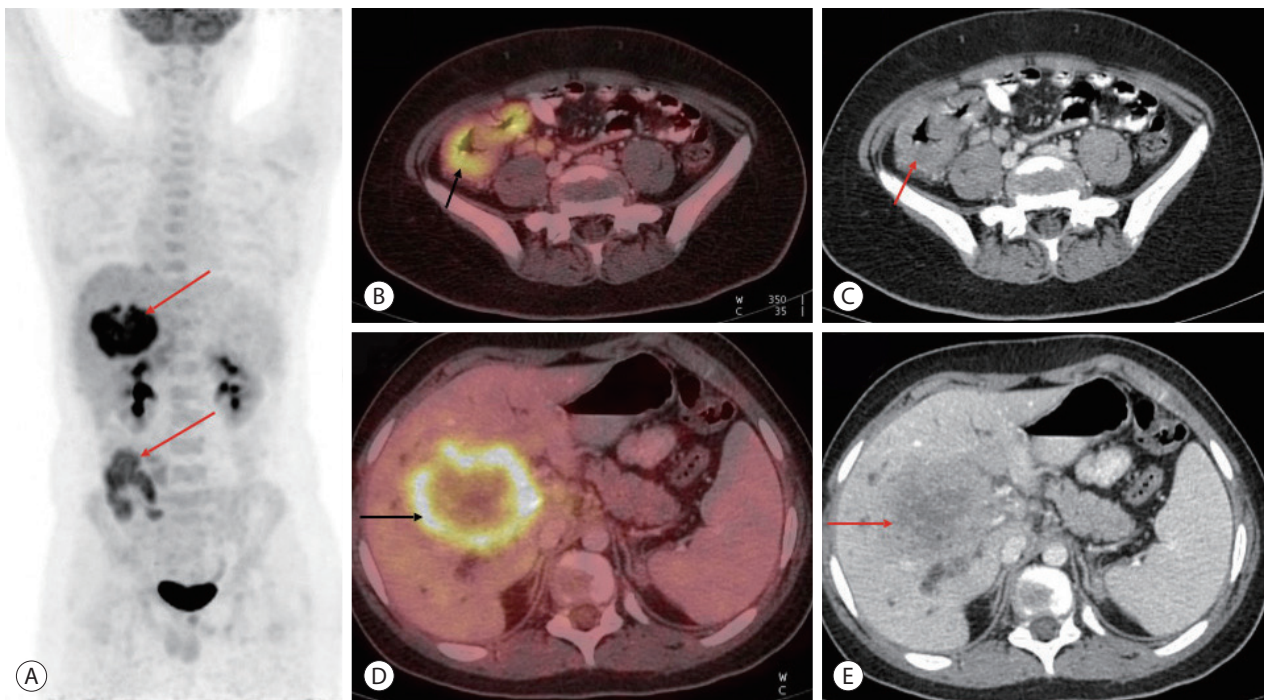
(A-C) Whole-body FDG positron emission tomography-computed tomography scan demonstrates FDG avid mass like ulcerated irregular thickening involving the cecum, distal ileum, and proximal ascending colon (red and black arrows) along with FDG avid paracecal lymph nodes. (D, E) A large, FDG-avid hypodense lesion showing heterogeneous post-contrast enhancement in the right lobe of the liver involving segments 5, 6, and 7 (red and black arrows) measuring approximately 7.0×8.0×6.4 cm in size. FDG, fluorodeoxyglucose.
